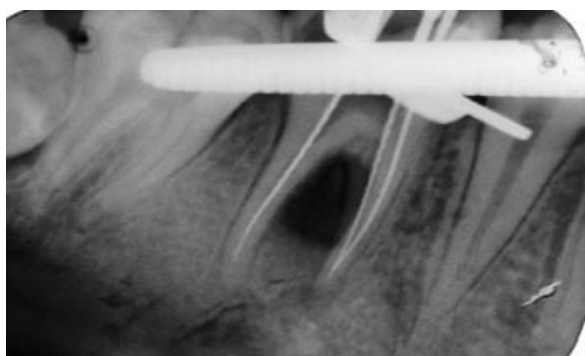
Periapical radiography of working length determination
